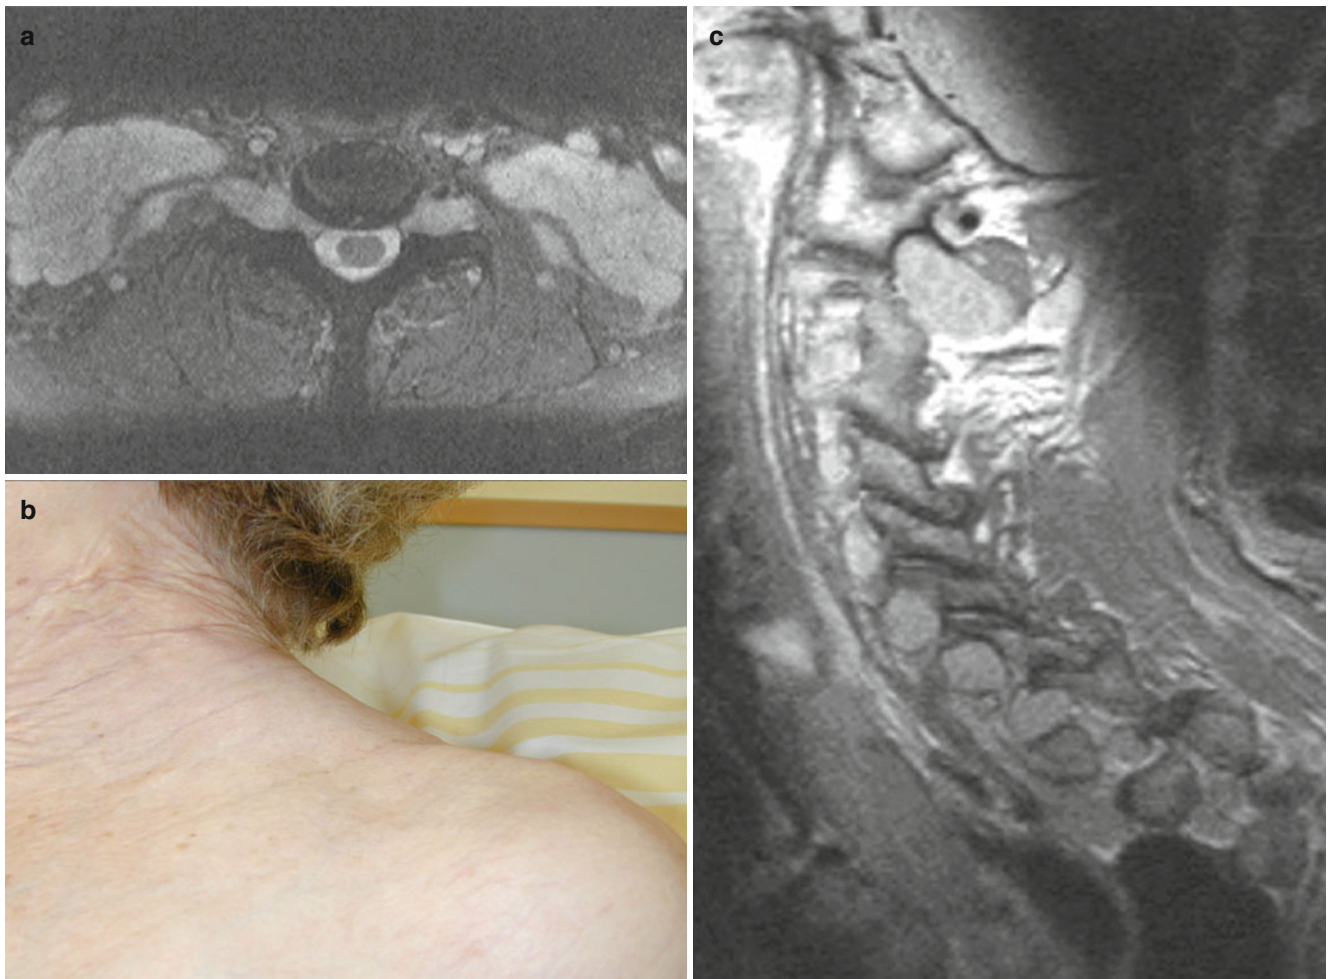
Neurofibromatosis and the brachial plexus. (a) MRI of the nerve roots and brachial plexus. Note tumorous enlargement of nerve roots and (c) brachial plexus. (b) Note the palpable supraclavicular mass
